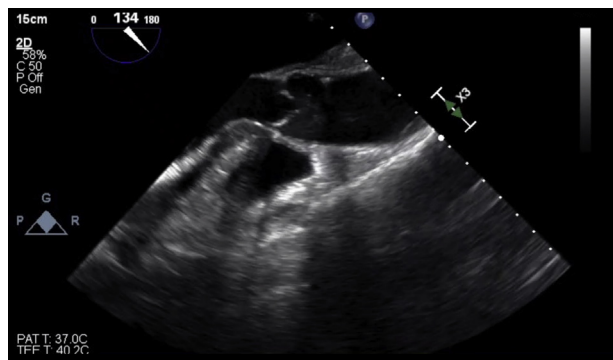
Midesophageal long-axis window by TEE, 1 day after device placement and with ECMO support wean, demonstrating clearing of the echocardiographic contrast from the ascending aorta.
